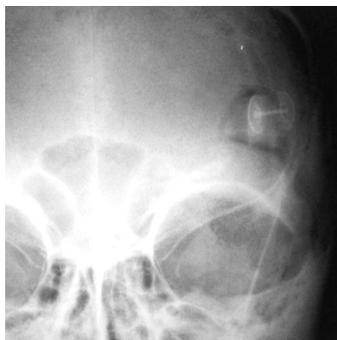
After extirpation of the brainstem cavernoma, in the postoperative plain x-ray, the limited supraorbital craniotomy is evident.
